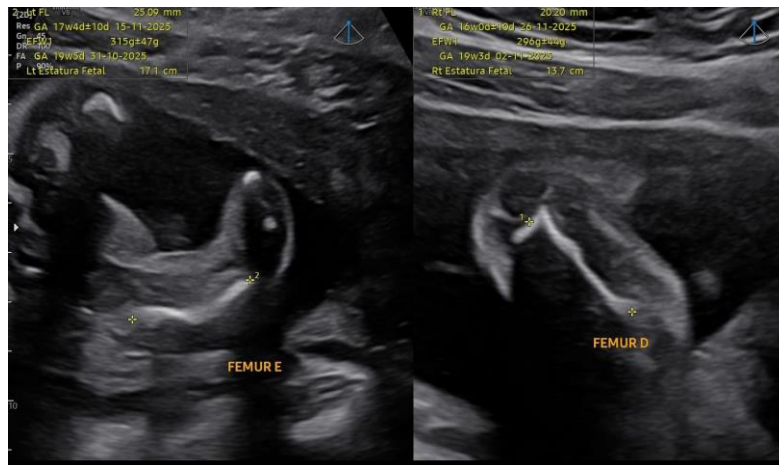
Obstetric ultrasonography showing shortening and bowing of the fetal long bones (femurs).
